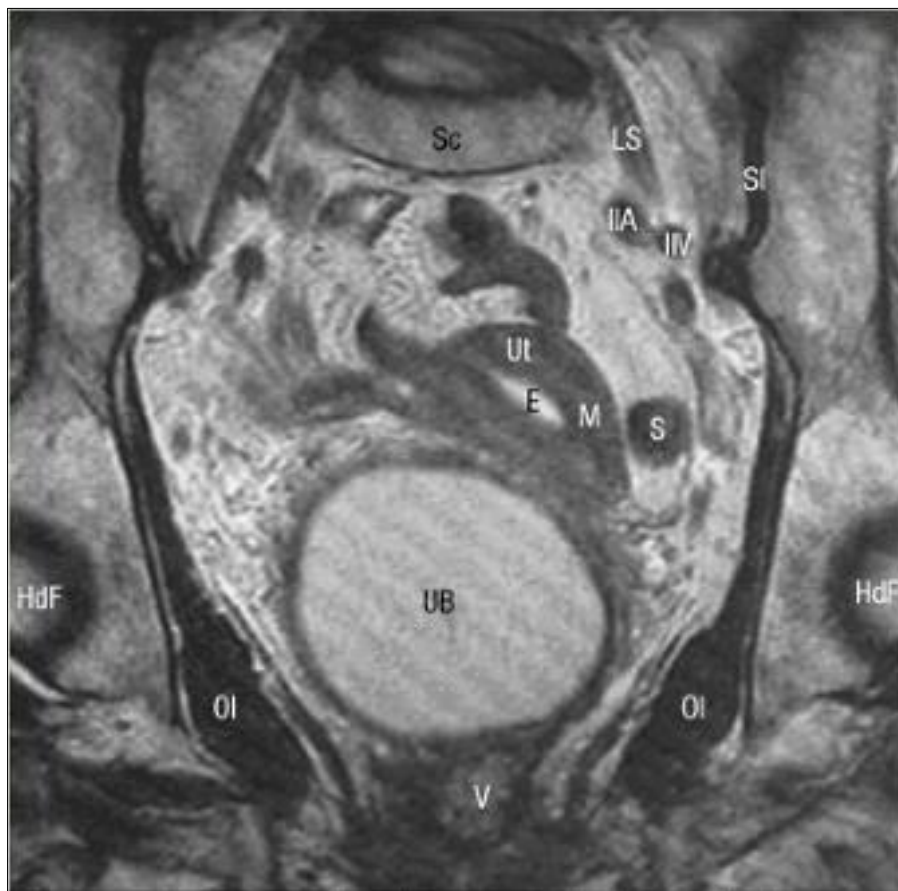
MRI of the female Pelvis. Courtesy; Keith Moore& Arthur Dalley
